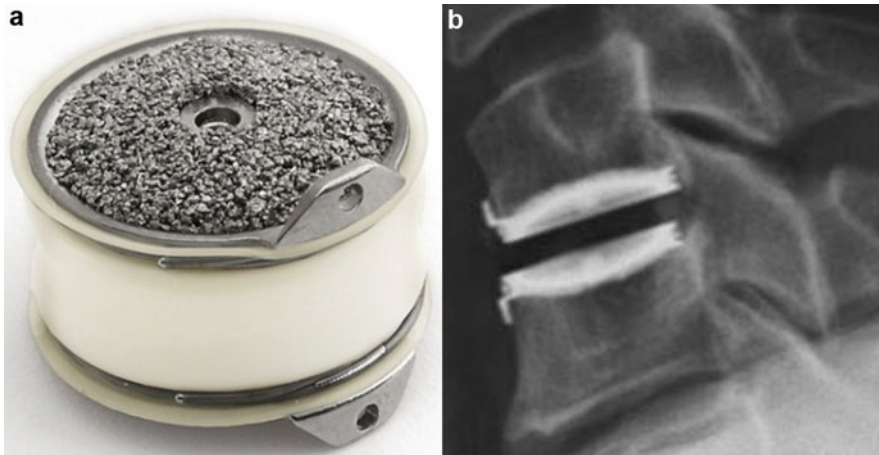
Bryan artificial disc: (a) device; (b) lateral X-ray after implantation
